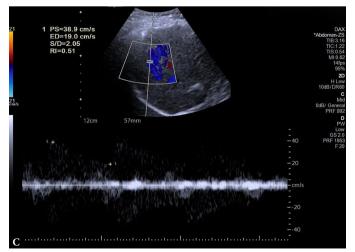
A 45-year-old man was diagnosed as with hemangioma. On B-mode ultrasound (BMUS), a  $45 \times 35$  mm mixed echoic mass was detected in the right lobe of the liver, with an ill-defined margin (A). Color blood signals were detected within the lesion (B) with resistance index (RI) of 0.51 (C)
